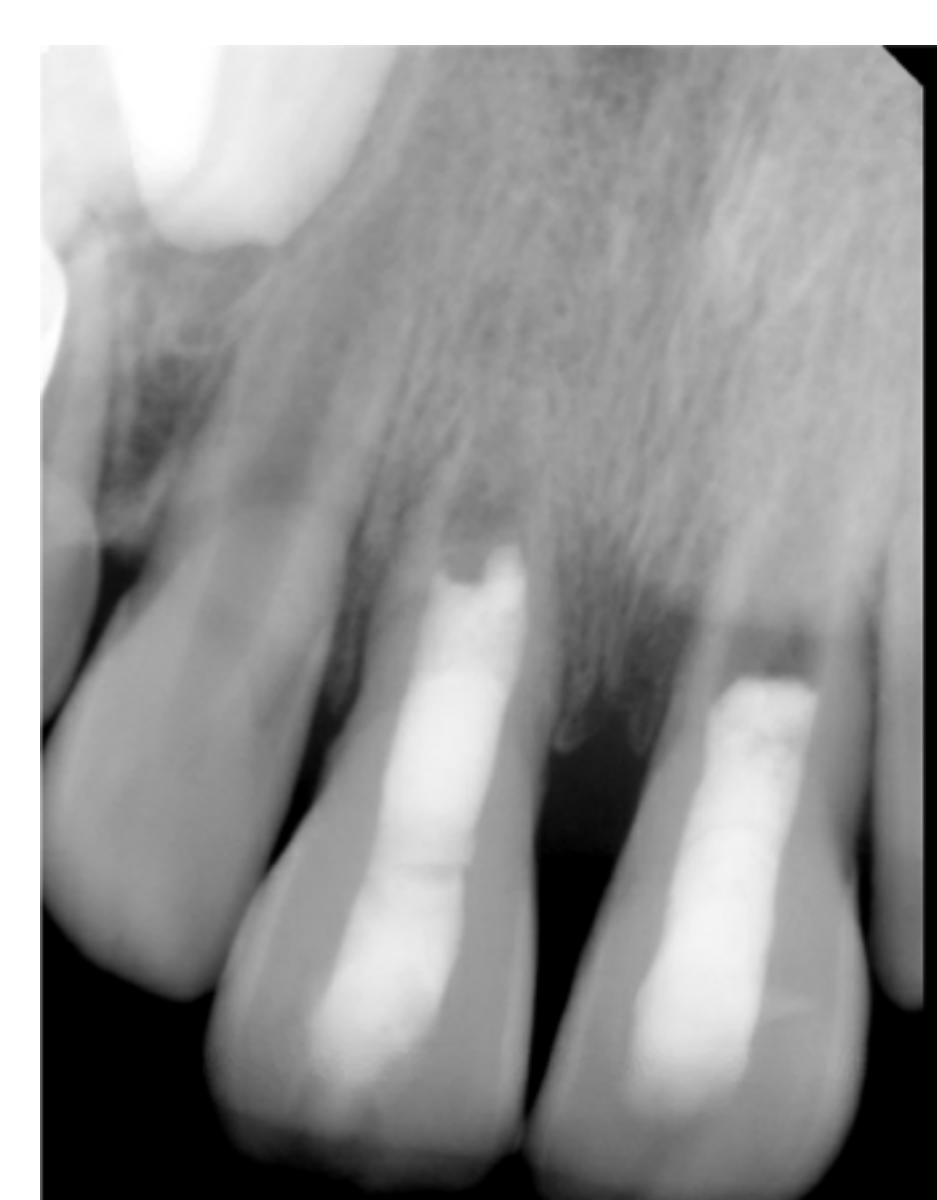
Initial implantation    Figure B. After apexification    Figure C. Day 168 radiograph
